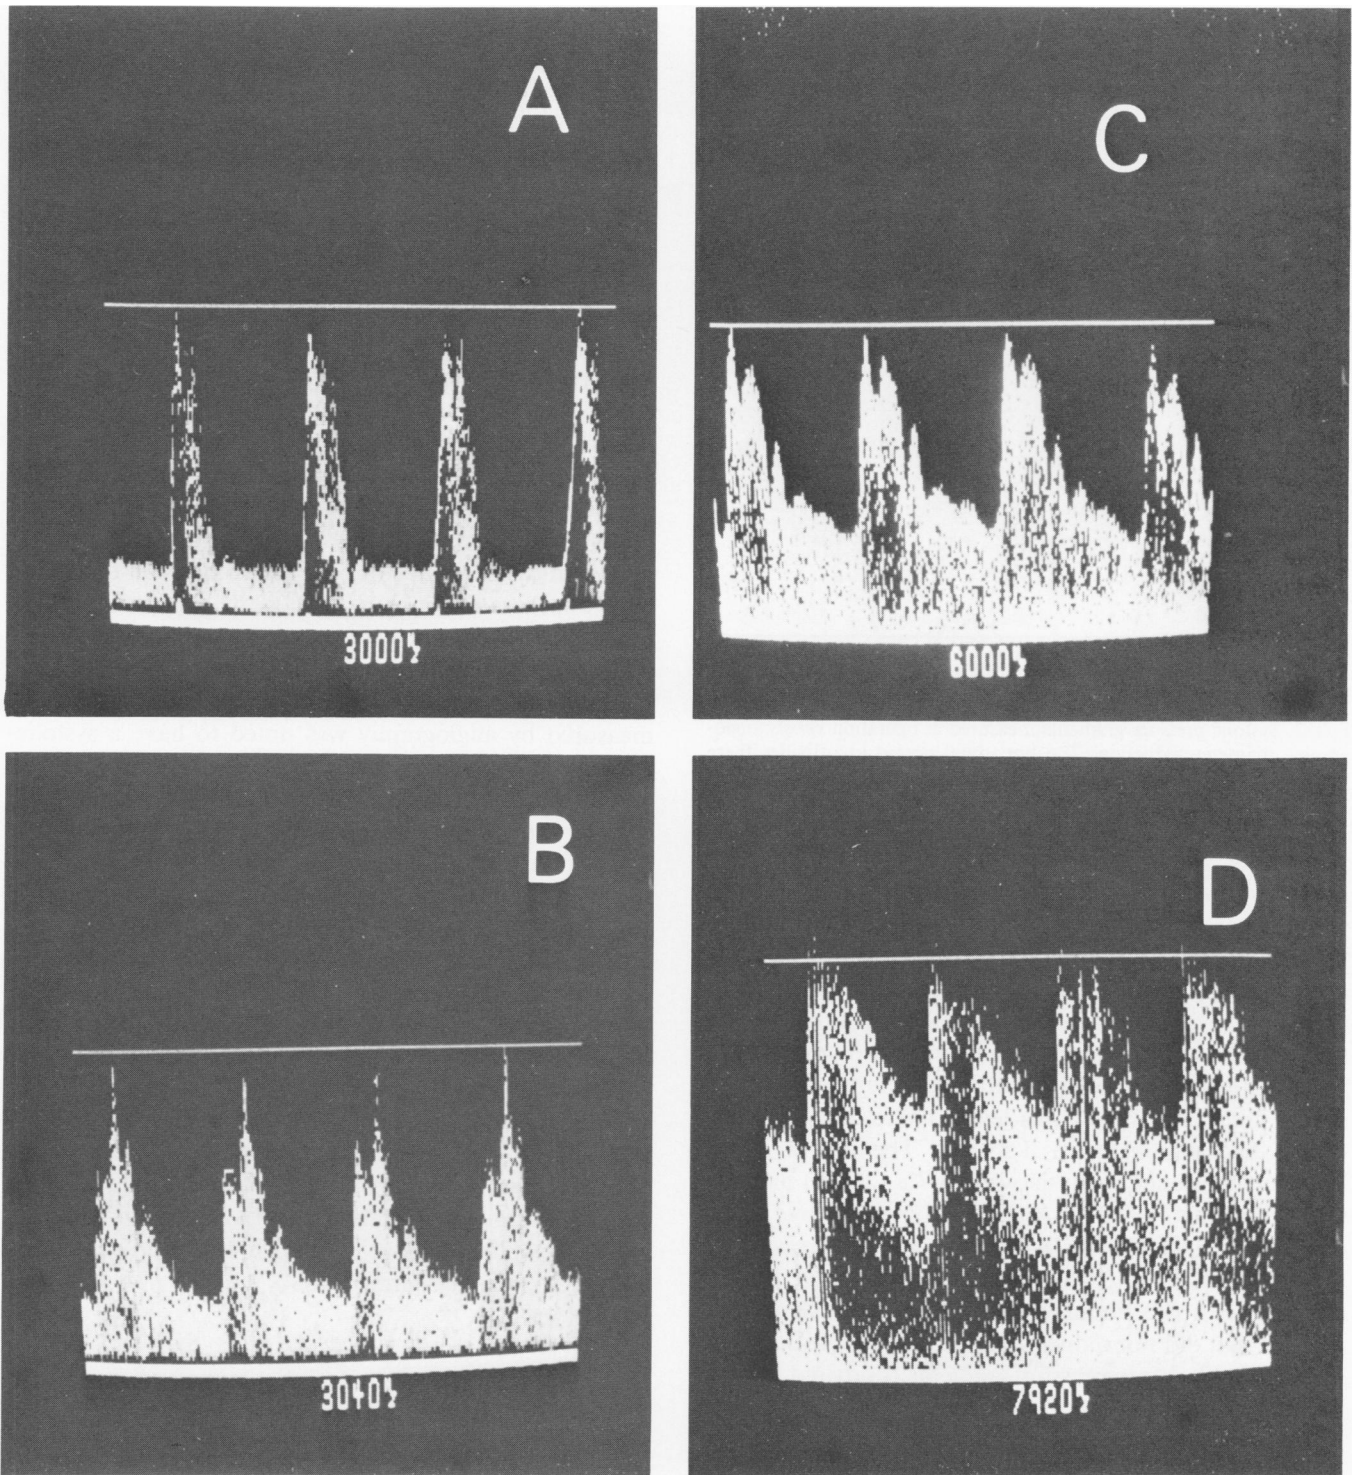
Pulsed Doppler spectra recorded from internal carotid arteries with varying degrees of disease determined by angiography. Spectrum A from a normal vessel exhibits a low peak frequency with no spectral broadening in systole. Spectrum B recorded from a mild 25% stenosis also has a low peak frequency with spectral broadening due to flow disturbance produced by the plaque. Spectrum C recorded from a moderate 50% stenosis shows disturbed flow associated with a moderate elevation of peak systolic frequency (6.0 kiloHertz), while spectrum D from a high grade 80% stenosis has a marked systolic frequency elevation (7.9 kiloHertz). (Scale on A and B 0-5 kiloHertz; scale for C and D 0-10 kiloHertz).
